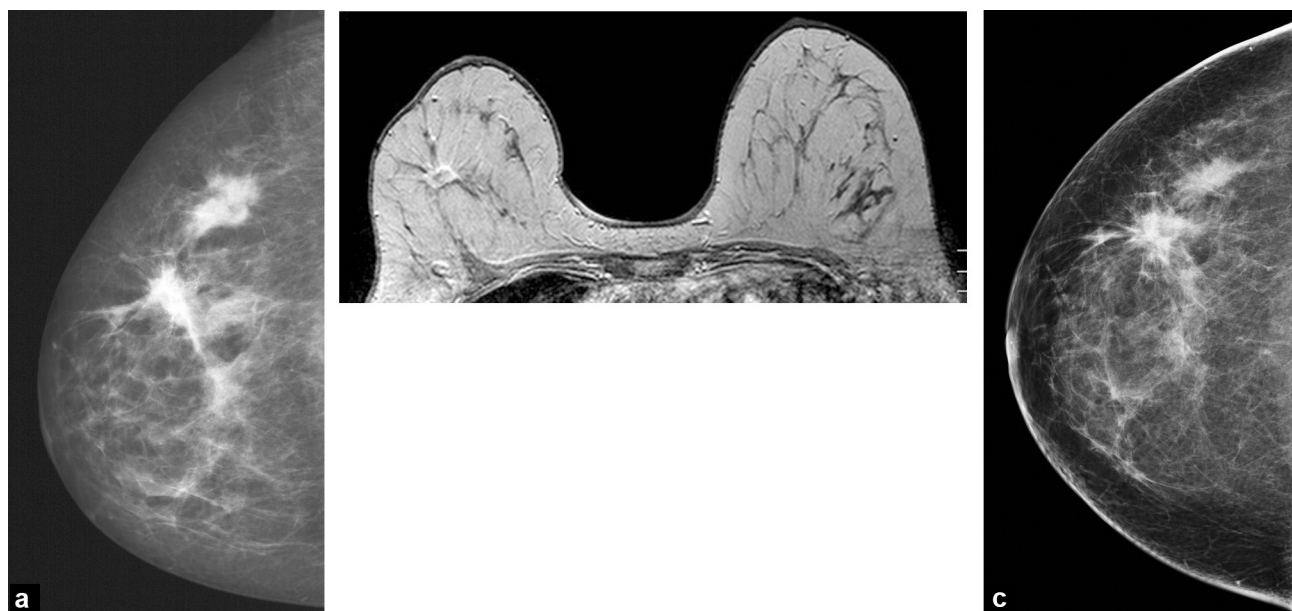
Luminal A sub-type. a: mammogram: spiculated (palpable) mass of 50mm. Infiltrating ductal carcinoma grade I, oestrogen receptors/progesterone receptors = 90%, Ki67 < 14%, HER2—. b: same patient. MRI after injection: irregular spiculated mass. c: same patient. Mammography control after 4 months of neo-adjuvant hormone therapy: reduction in the size of the mass.
